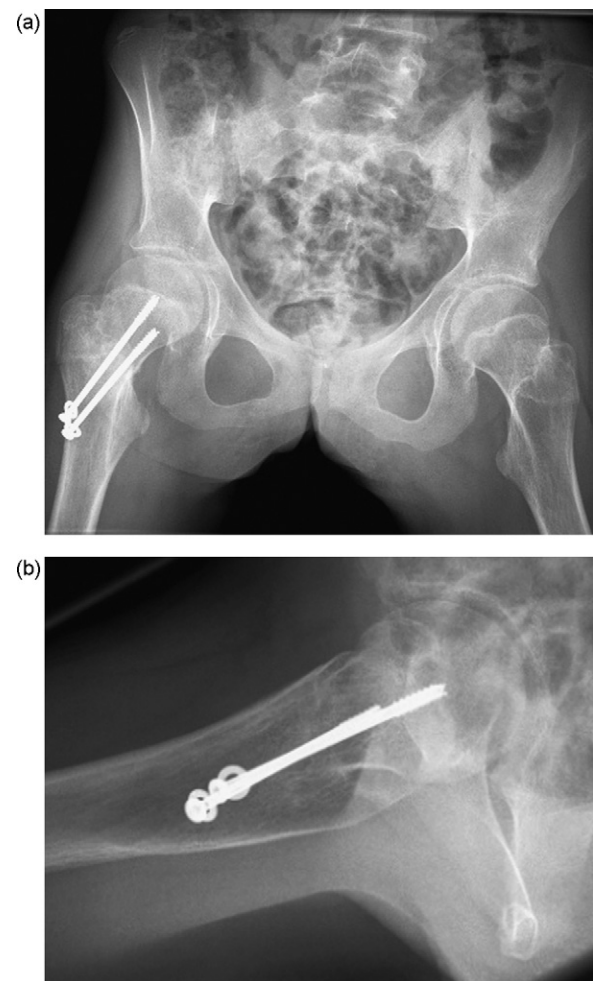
(a) Post-operative antero-posterior radiograph of patient's pelvis and (b) post-operative lateral radiograph of patient's right hip.
